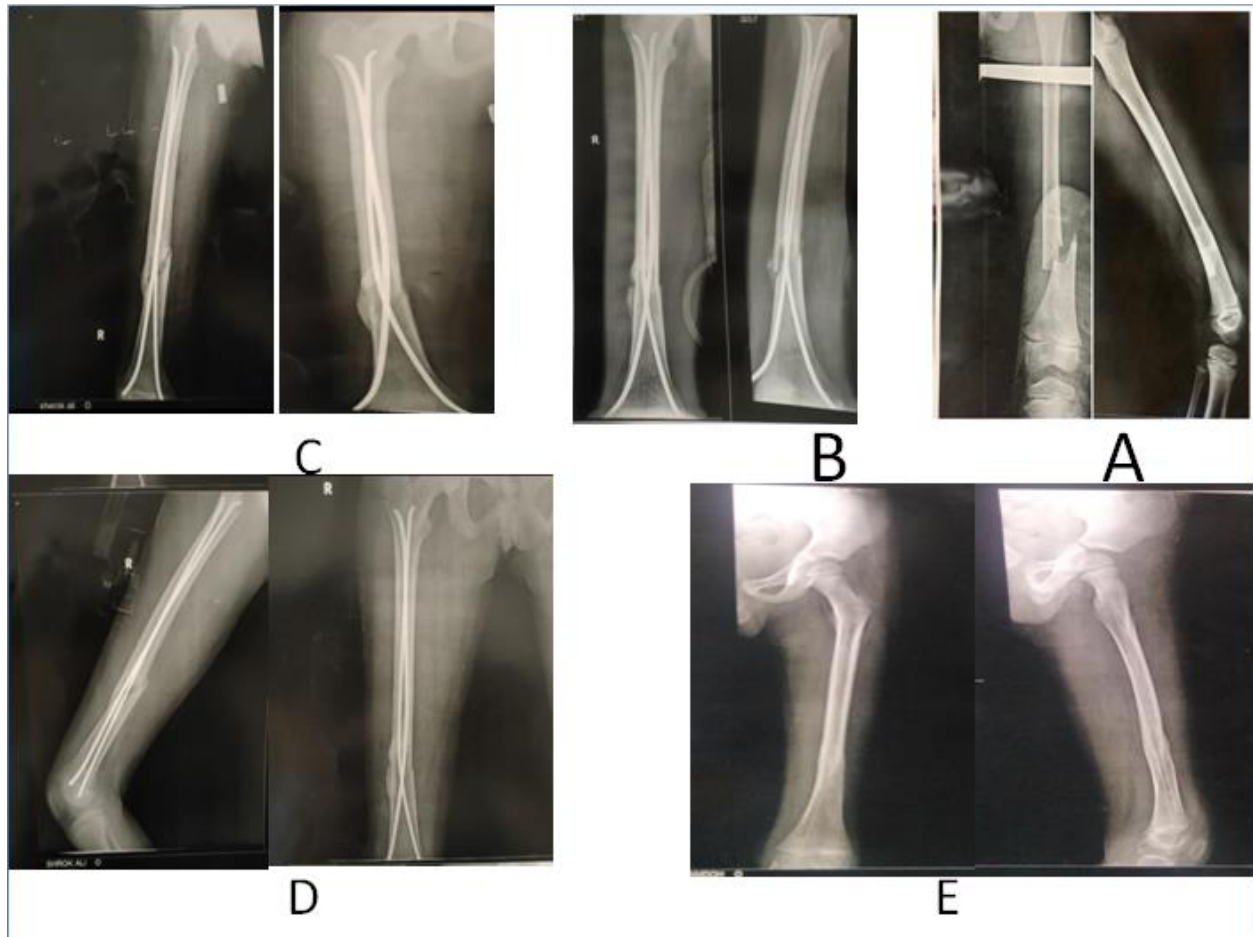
case 2, Female child, 6 Years old, with fracture of distal 1/3 left side femur. A) Antero-posterior and lateral X-ray of the right femur showed an oblique fracture. B) one-month postoperative x-ray AP and Lateral views showed fixation with 2 ESIN. C) 8 weeks postoperative X-ray AP and Lateral views showed fracture callus consolidation, D) 3 months postoperative X-ray AP and Lateral views showing incomplete fracture healing. E) one year followup after ESIN removal show complete fracture union
